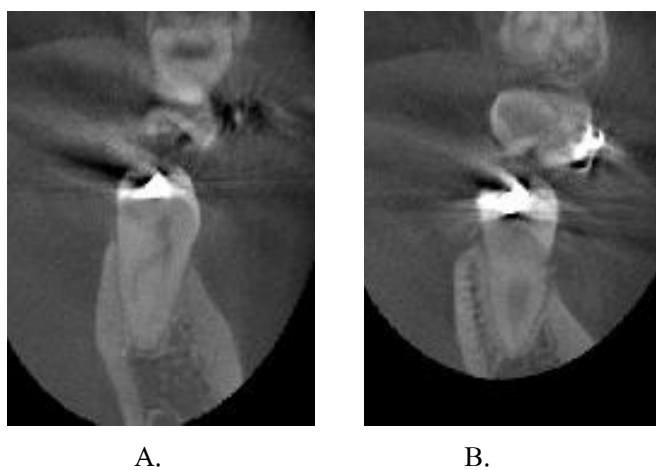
CBCT were assessed the buccal and lingual marginal bone level at mid-mesial root (A) and at mid-distal root (B).
